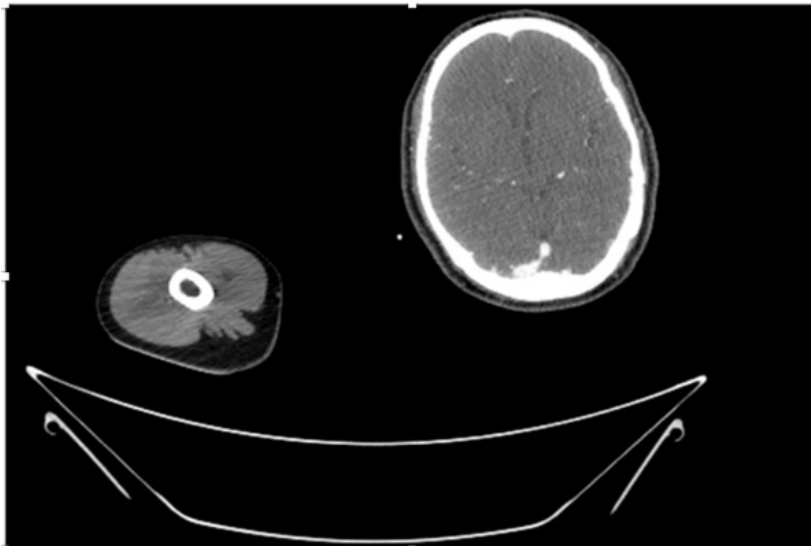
CT Angiogram at lower arm showing totally occluded right brachial artery.
